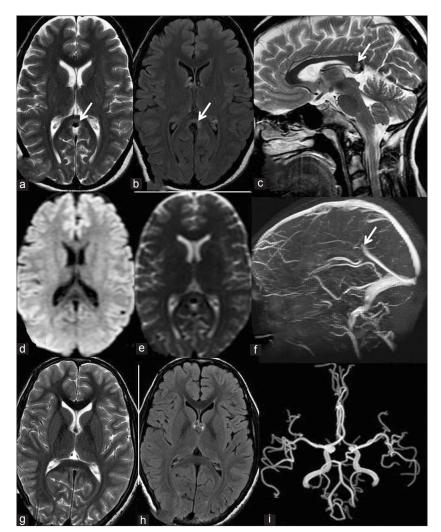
Magnetic resonance imaging, magnetic resonance angiography and magnetic resonance venography (Brain) of case 3, with hemicrania continua, showing semilunar hyperintensity ("mini-boomerang") on axial T2-weighted (a) and fluid attenuated inversion recovery (b) images with a focal hyperintensity on sagittal T2-weighted image (c); there was no evidence of restriction on diffusion-weighted image (d) and the apparant diffusion coefficient map (e) was normal. Lack of proper visualization of veins at the level of vein of Galen was evident on magnetic resonance venogram (f). Repeat T2-weighted image (g) and fluid attenuated inversion recovery image (h) at 3 months showing complete resolution of the abnormal signals in splenium. Magnetic resonance angiogram (i) did not reveal any abnormality
